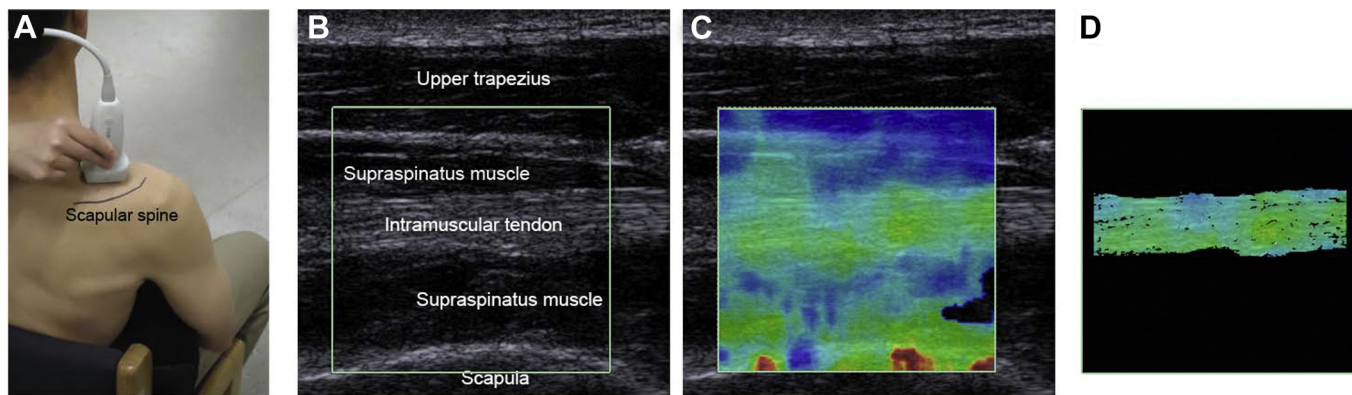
Ultrasound shear wave image acquisition of the supraspinatus intramuscular tendon with the transducer placed just anterior to the scapular spine (A), the resulting B-mode (B) and shear wave elastography (C) images, and extraction of the relevant shear wave values for analysis using image segmentation (D).
